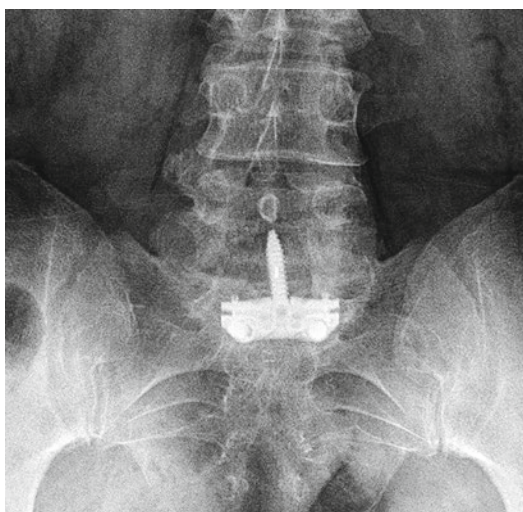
Postoperative anteroposterior radiograph shows interbody cage device
